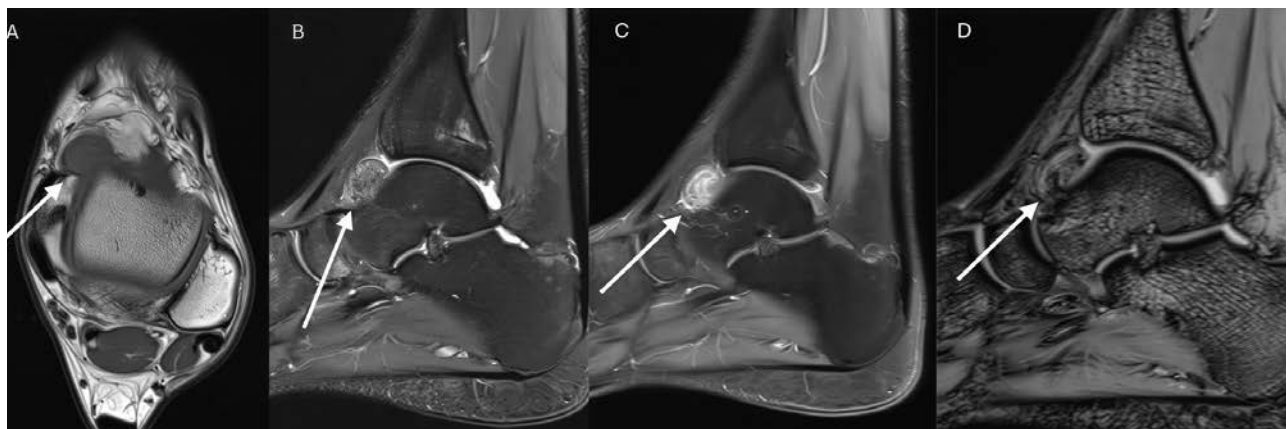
MRI of the ankle demonstrates a localized intra-articular TSGCT, presenting as a well-circumscribed nodular lesion along the anterior tibiotalar joint recess (arrows). The lesion shows low-to-intermediate signal intensity on non-contrast T1-weighted and intermediate-weighted images (arrows, A and B). On post-contrast T1-weighted imaging, it demonstrates marked, heterogeneous enhancement (arrow, C), representing the cellular stroma. These findings are typical for localized intra-articular TSGCT and aid in differentiation from cystic or non-enhancing synovial lesions. Gradient-echo imaging demonstrates clear blooming artefact (arrow, D), reflecting hemosiderin deposition and supporting the diagnosis of localized intra-articular TSGCT.
